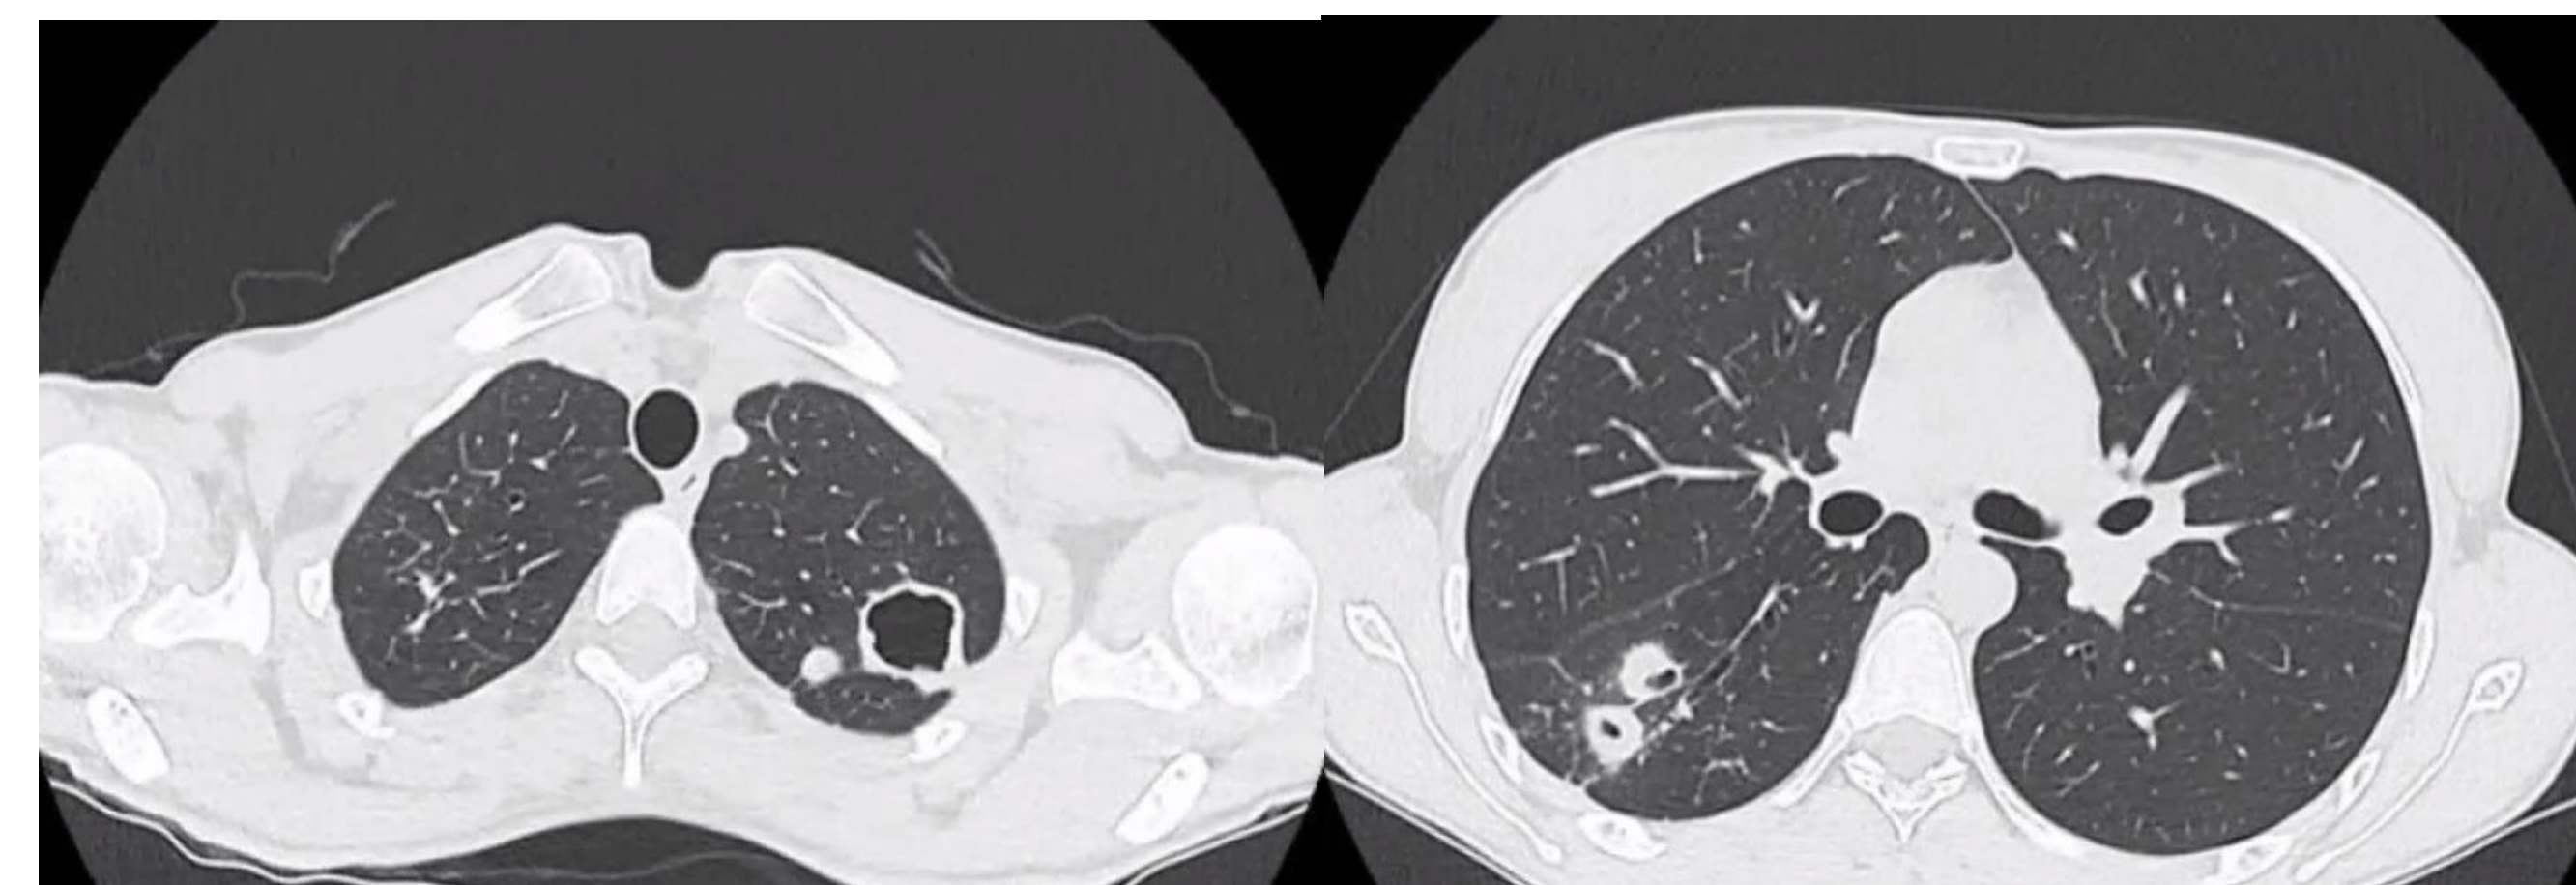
First Chest CT scan with which the patient came to the attention of our Unit. It shows bilateral lung cavities and nodules predominantly in the upper lobes.
